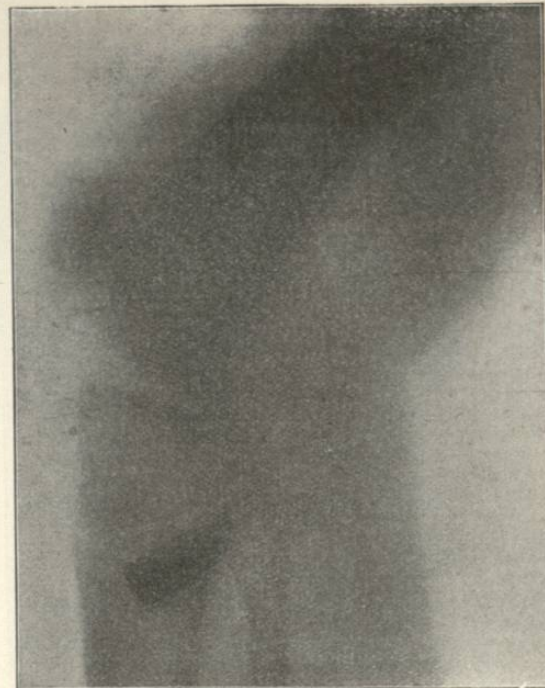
Radiograph. Case of T. H.—, showing Mauser bullet lodged above and posterior to the hip-joint. Wounded July 1st, 1898. Radiograph taken October, 1901. The ball entered base first, passing through upper left arm and entering body opposite sixth rib in the mid-axillary line; it passed down to position seen in radiograph.
